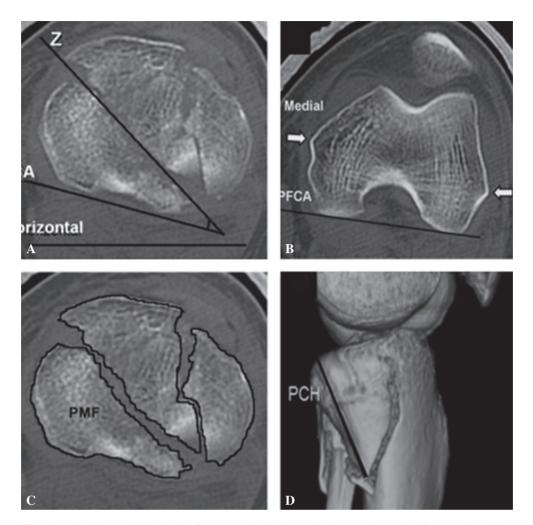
A : The medial articular fracture angle is the angle between the major fracture line of the medial tibial plateau (Z) and the posterior femoral condylar axis (PFCA). B : The posterior femoral condylar axis (PFCA) is the line connecting the posterior aspects of the femoral condyles in the transverse cuts at the level of the epicondyles (whit arrows) of the ipsilateral distal femur. It acts as a neutral axis of the coronal plane. C : The cephalad surface area percentage of the posterior cortical height (PCH) is obtained by measuring the straight-line distance from the most distal extent of the fragment to the most posterior aspect of its articular surface on the sagittal CT.
